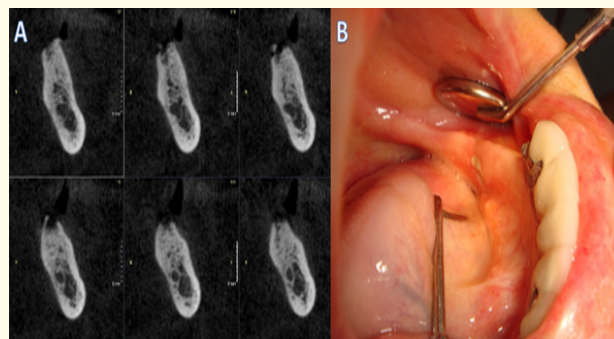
CBCT-Cross section images of the patient's left molar site of the mandible. Note the destruction and osteosclerosis at the bone.
